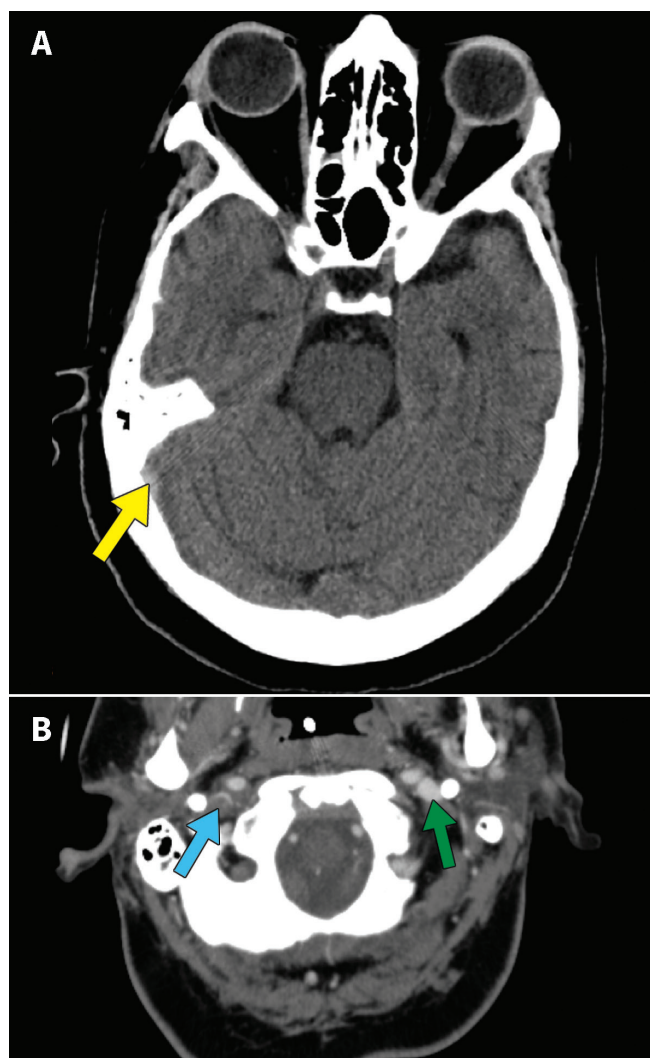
Computed tomography (CT) scans of the head of a 46-year-old woman with cerebral venous sinus thrombosis. (A) Unenhanced CT (axial slice), showing a subtle focal high density in the right lateral transverse sinus into the junction with the right transverse sinus (arrow) and in the right sigmoid sinus (not shown), raising concern for acute dural venous thrombosis. There is no associated edema or hemorrhage. (B) CT venogram, showing near occlusive thrombosis in the right internal jugular vein (dark grey) just below the level of the skull base (blue arrow). Extensive acute thrombosis extended to the right sigmoid sinus and jugular bulb (not shown). Contrast is seen on the contralateral side (light grey), indicating patency (green arrow).
